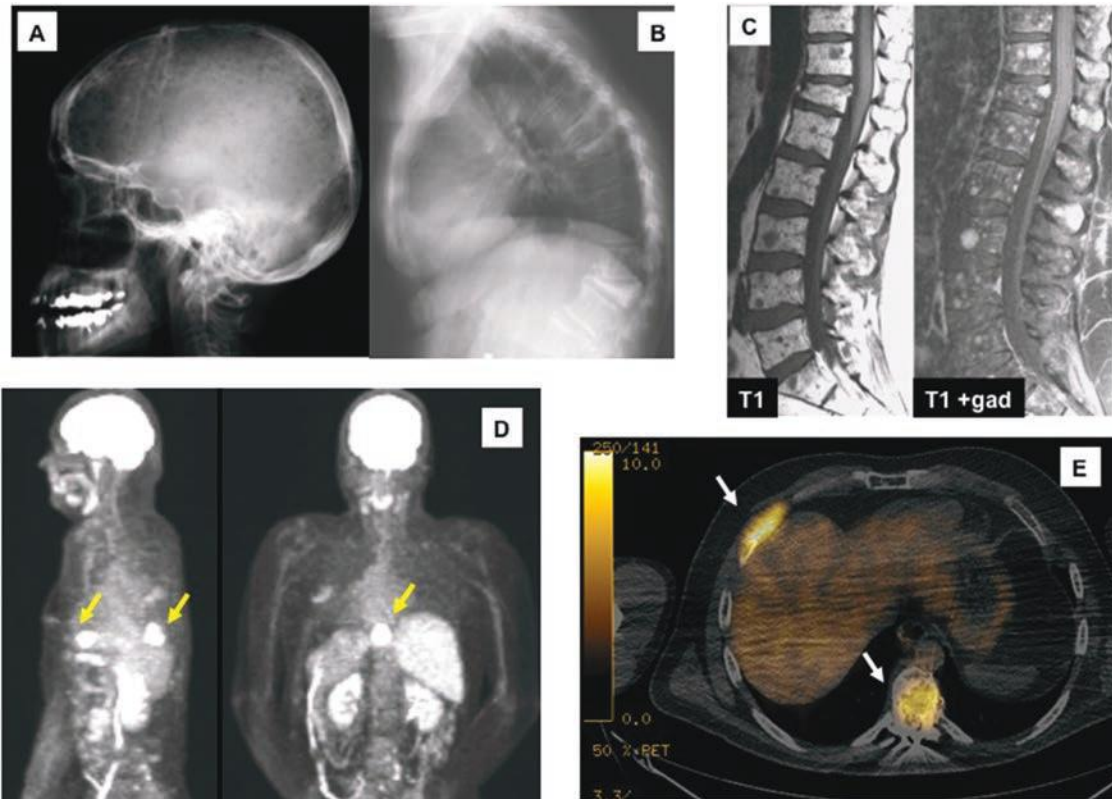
Myeloma bone disease. A: Plain radiograph of a skull with punched-out myeloma lesions. B: Plain radiograph of a compression fracture thoracic spine. C: Myelomatous marrow involvement of the lumbar spine by magnetic resonance imaging (MRI) with and without gadolinium. D: 18-Fluorodeoxyglucose positron emission tomography (FDG-PET), spine and rib involvement. E: Fusion image of CT/FDG-PET scan demonstrating lesion at rib and thoracic vertebra.
